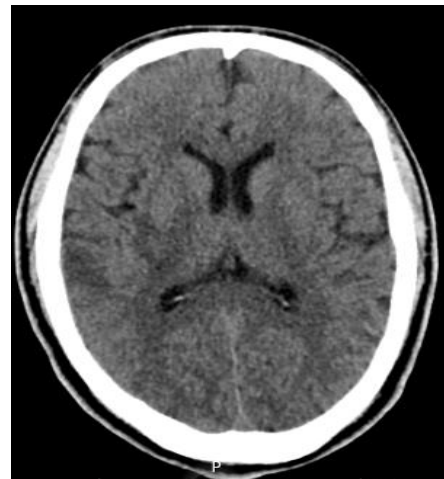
Head CT An axial within the ventricular level, we can find an hypodense lesion with poorly defined borders, located in the right parietal and temporal region.
